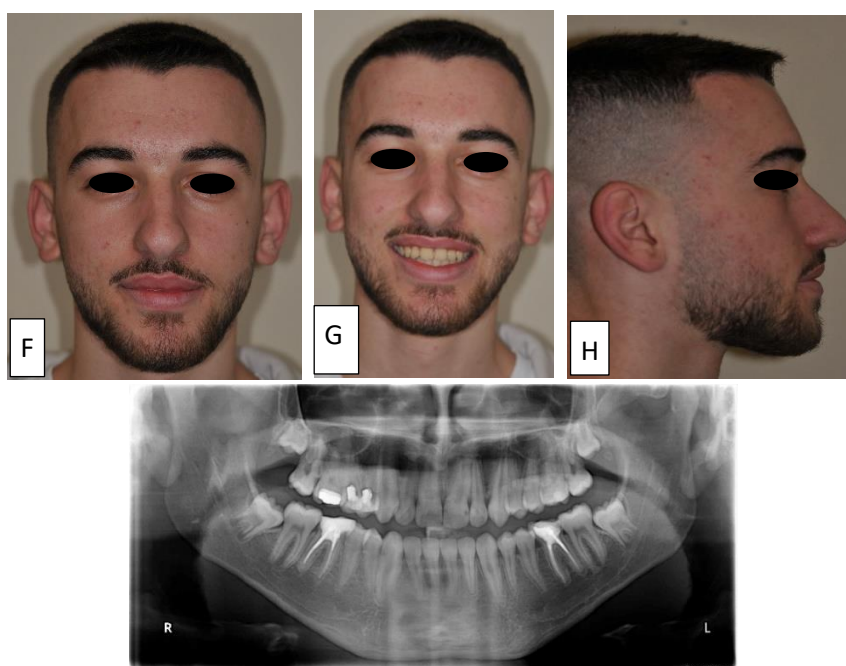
Intraoral, face, and profile post-treatment; panoramic radiograph.
